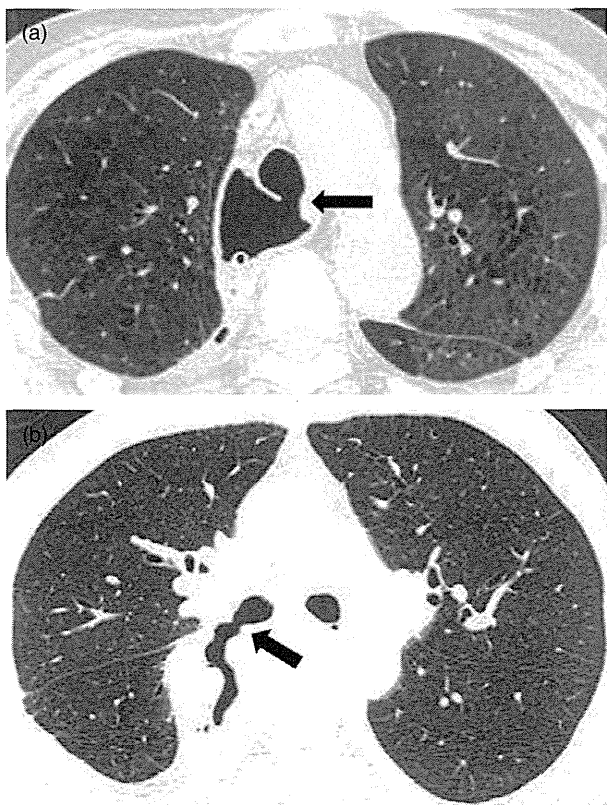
CT scan features of GTF. The presence of GTF was confirmed by fiberscopy, while the location was well recognized on the CT scan. (a) TGF in the trachea near the carina in Patient 8. (b) A huge TGF in the right bronchus that had been treated surgically in another hospital, but the treatment was unsuccessful (Patient 10).
